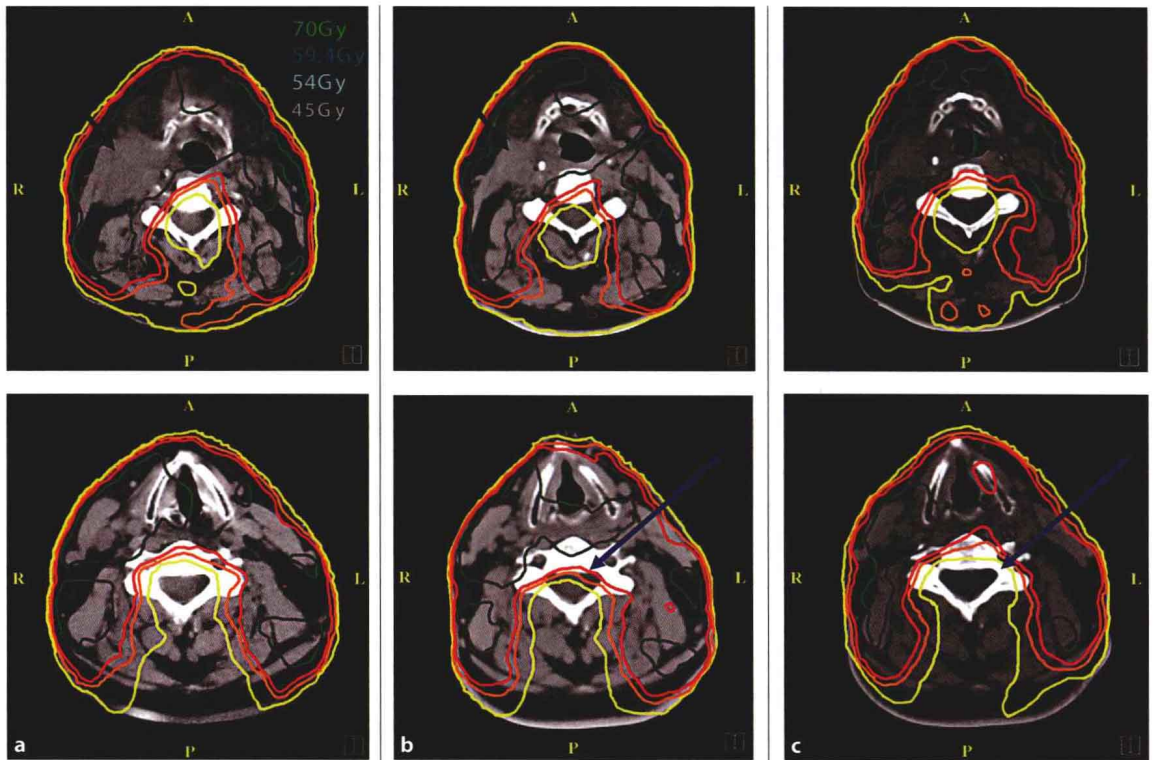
IMRT treatment isodoses for a T4N2c base of tongue cancer in a 54-year-old male. Top row: level of hyoid bone; bottom row: lower neck. a CT 1: initial plan, before therapy. b CT 2: same plan shown on repeat CT scan after 21 fractions; tumor has regressed (black arrow) and patient has lost 5% of his body weight. Note that spinal cord dose has become unacceptable (blue arrow). c CT 2: reoptimized plan.
